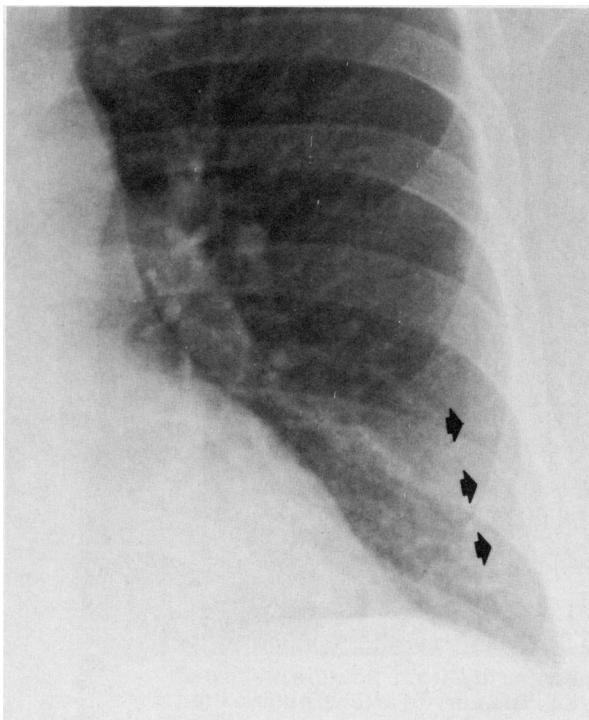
The serratus anterior muscle, demonstrating the hazy appearance that the muscle causes on the PA chest radiograph (arrows)
